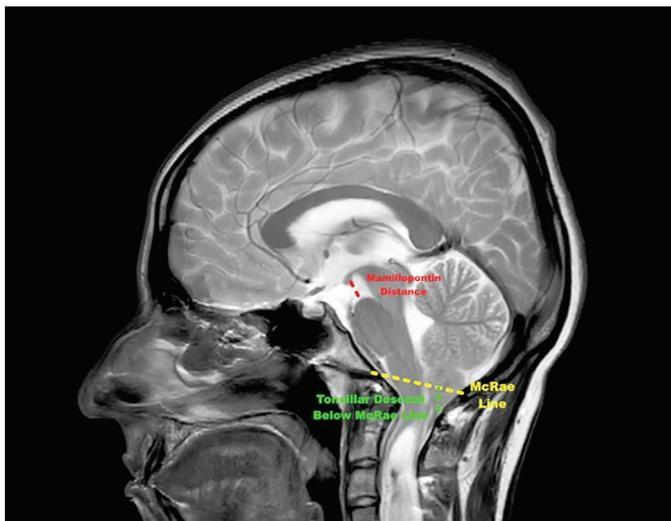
Measurement of tonsillar ectopia (TE) and mamillopontine distance (MPD) on mid-sagittal magnetic resonance imaging. The McRae line is drawn between the basion and opisthion. TE is defined as the maximum vertical distance of the cerebellar tonsils below this line. MPD is measured between the inferior margin of the mamillary bodies and the superior surface of the pons
